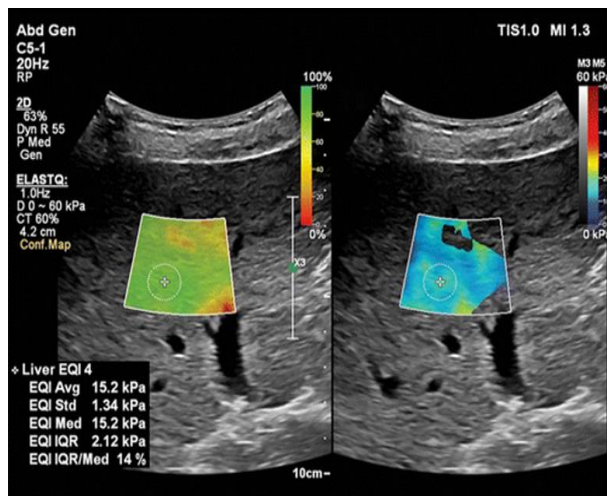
Liver ultrasound elastography [56]
